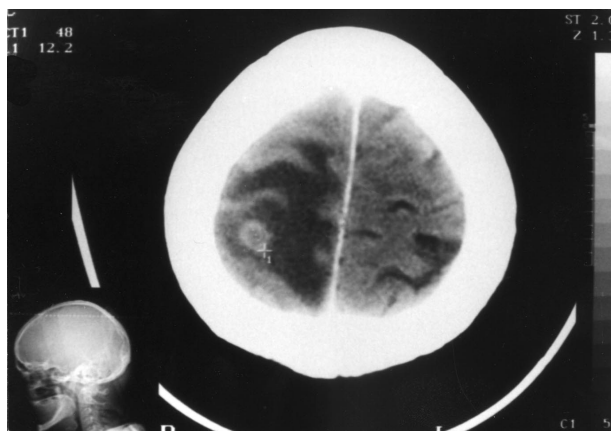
Homogeneous well outlined focal lesion 12x11mm in size, in the right parietal lobe greatly enhanced by contrast injection (in CT and MRI). In intraoperative USG the tumour was hyperechogenic (Fig. 1e). Extensive oedema around the lesion – visible in Fig. 1a,b,c as hypodense area (in CT) and hypointense area in SE T1 images, and hyperintense in FSE T2 images (Fig. 1d).
